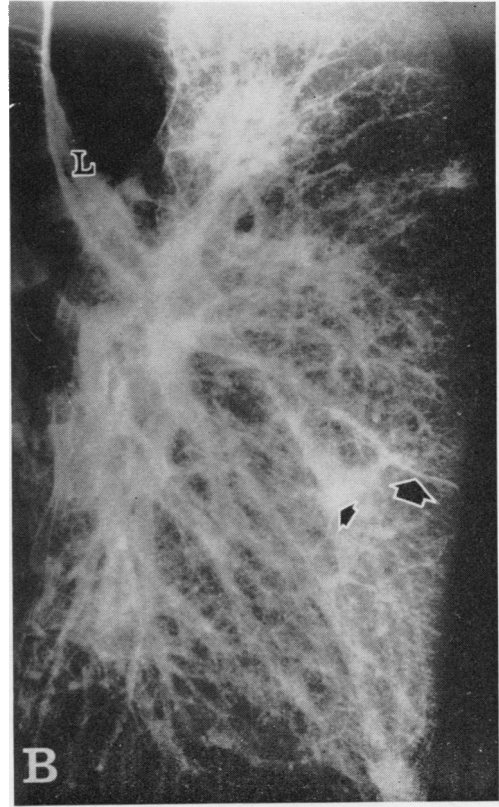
(B) Radiograph of left lung after insufflation showing appearance of line shadows.
